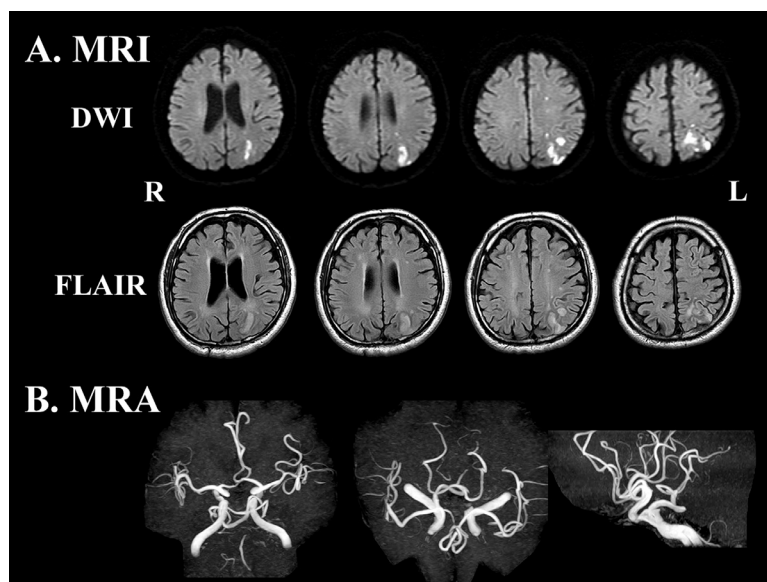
(A) Diffusion-weighted imaging (DWI) and fluid attenuated inversion recovery (FLAIR) imaging demonstrated high signal intensity lesions in the posterior cerebral–middle cerebral artery and anterior cerebral–middle cerebral artery watershed areas of the left parieto-occipital and frontal lobes. (B) No intracranial artery stenosis was recognized on magnetic resonance angiography (MRA). However, a large persistent primitive trigeminal artery originated from the cavernous portion of the right internal carotid artery and terminated on the distal portion of the basilar artery, presumably supplying blood to the posterior circulation. The basilar artery was aplastic proximal to its junction with the primitive artery and both vertebral arteries were hypoplastic. Posterior communicating arteries were not identified on either side.
